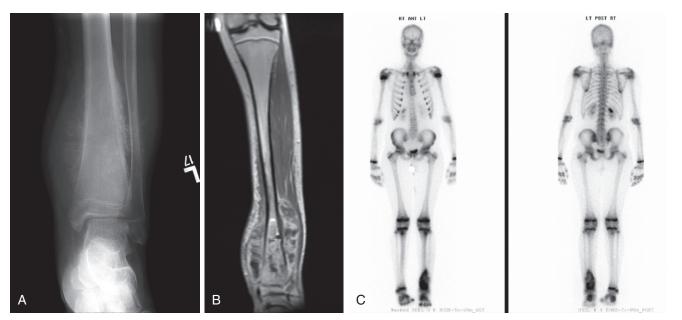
Osteosarcoma. A, Plain x-ray of the lower extremity in a child with newly diagnosed osteosarcoma. Note the soft tissue swelling, calcification, cortical bone destruction, and new bone formation. B, Coronal T₁ with contrast further defines the primary tumor. C, Bone scan of a young girl with osteosarcoma to evaluate the primary site for evidence of metastatic disease. Uptake is limited to the site of her primary tumor.
